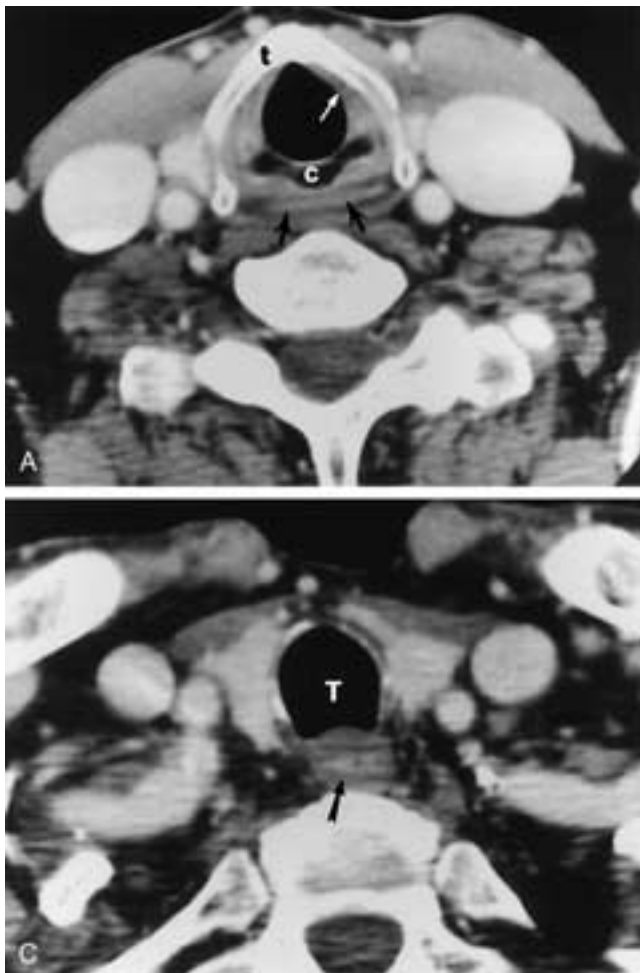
Axial CT scans through the normal postcricoid region. A, The postcricoid mucosa (*black arrows*) is slightly more dense than the wall. This image is at the level of the cricoid cartilage (*c*), thyroid cartilage (*t*), and inferior surface of the true vocal cords (*white arrow*). B, Barium shows the location of the lumen of the postcricoid hypopharynx (*arrows*). Cricoid cartilage (*c*). Thyroid cartilage (*T*). When not distended by air, the shape of the postcricoid hypopharynx is a flattened oval. C, Axial CT scan through the upper cervical esophagus for comparison. Instead of the flattened oval of the hypopharynx, the cervical esophagus is round (*arrow*) and indents the membranous posterior wall of the trachea (*T*).
